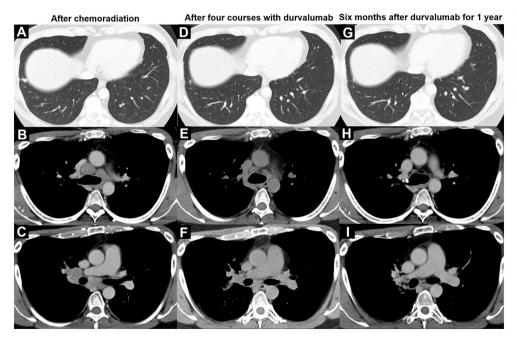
Findings of the chest computed tomography imaging during the treatment course: (A, B, and C) after chemoradiotherapy, the left pulmonary lesion and mediastinal/hilar lymph nodes showed stable disease; (D, E, and F) after the fourth round of durvalumab, the left pulmonary lesion and mediastinal/hilar lymph nodes exhibited a partially good response; (G, H, and I) 6 months after durvalumab administration for 1 year, the left pulmonary lesion and mediastinal/hilar lymph nodes did not show recurrence.
